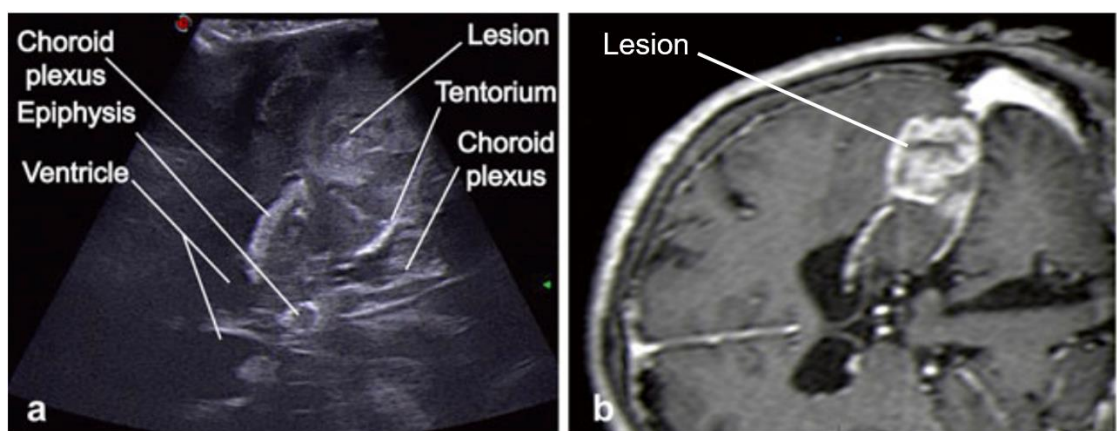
(a) A case of a temporal high-grade glioma is shown using 7 MHz IUS. The lesion appears hyperechoic on the IUS image but the margins surrounding the cancerous region are not well delineated and the image is of significantly lower resolution than the preoperative MRI in (b) [19].
